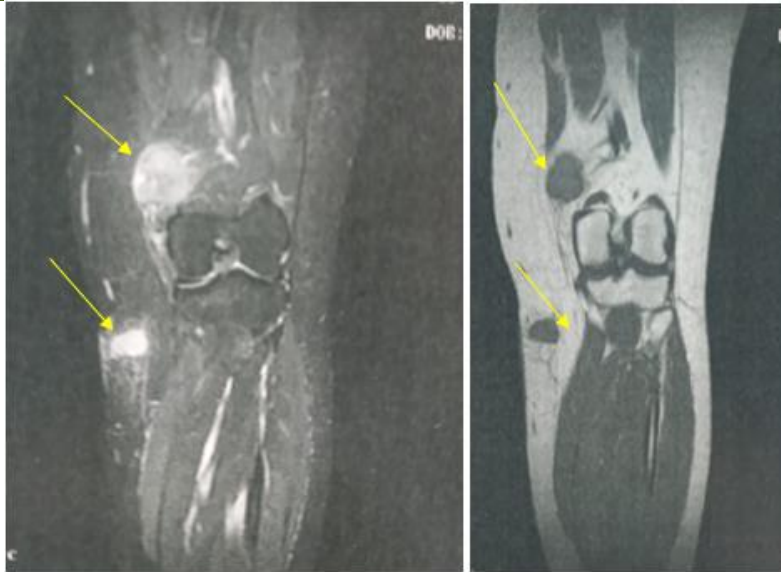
Magnetic resonance imaging of the left thigh and leg demonstrating two distinct soft-tissue masses measuring 38×34 mm and 26×19 mm, respectively. The yellow arrows indicate the location of the lesions. Based on their imaging characteristics, the lesions were initially considered suggestive of peripheral nerve sheath tumors or other soft-tissue neoplasms
